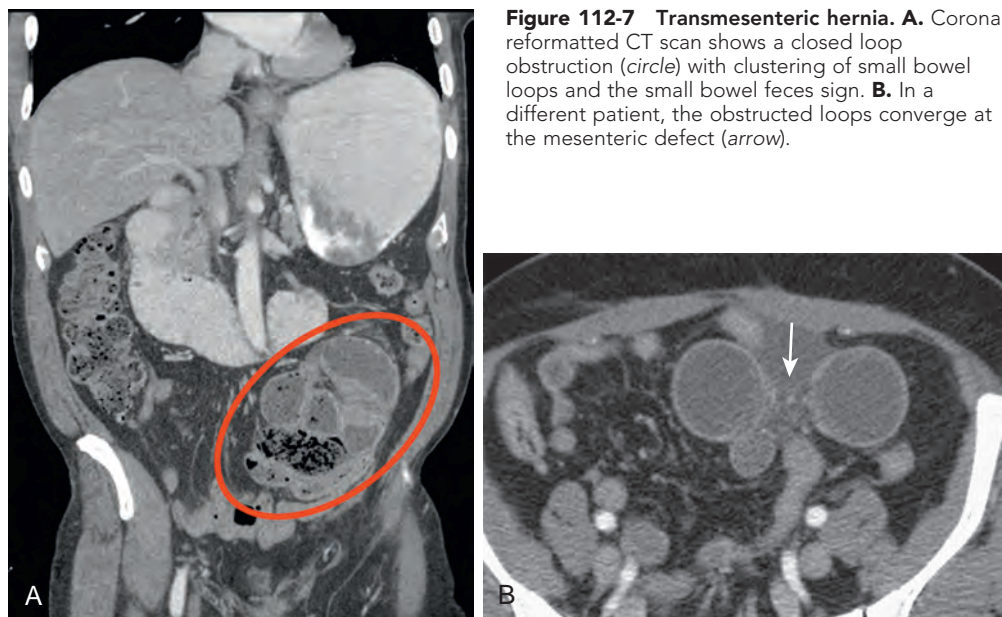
Transmesenteric hernia. A. Coronal, reformatted CT scan shows a closed loop obstruction (circle) with clustering of small bowel loops and the small bowel feces sign. B. In a different patient, the obstructed loops converge at the mesenteric defect (arrow).
